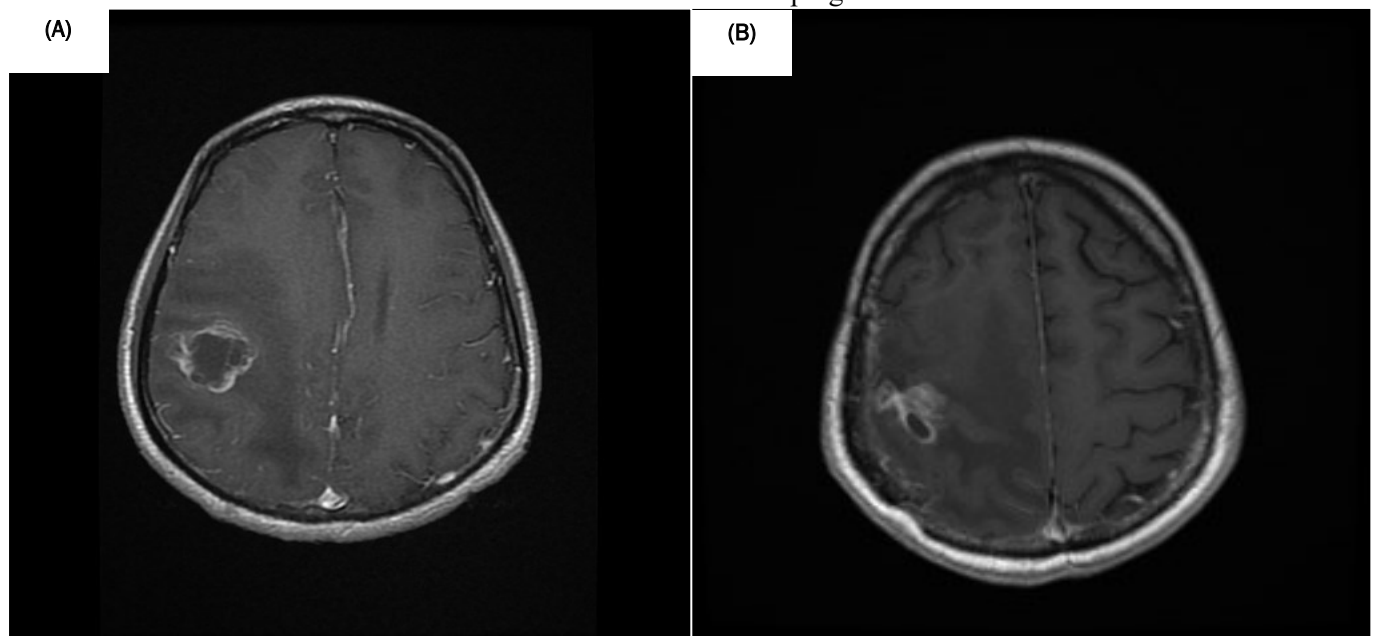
(A) Pre-radiation and (B) six-month post-radiation brain MRI scan of patient AN, showing a reduction in size of the metastatic lesion
